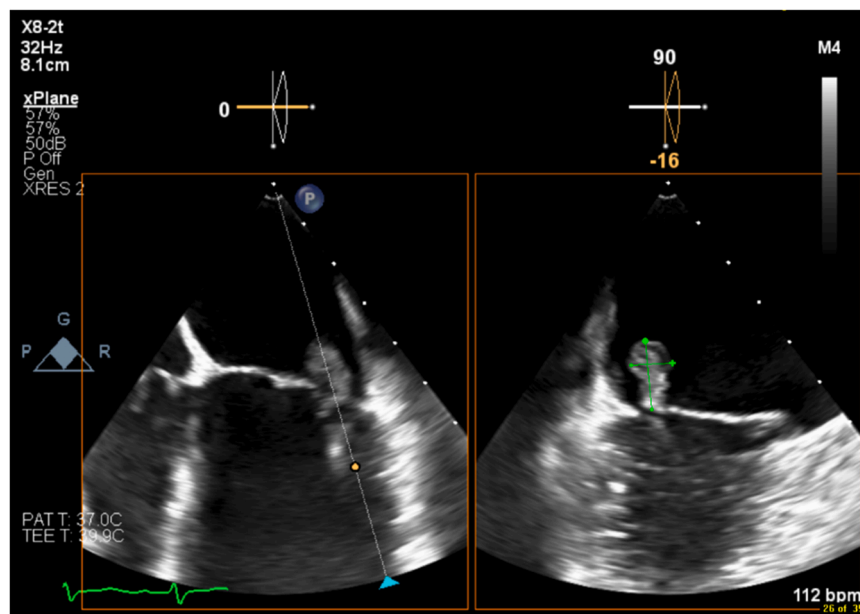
Echocardiogram with view of mitral valve and vegetation.
